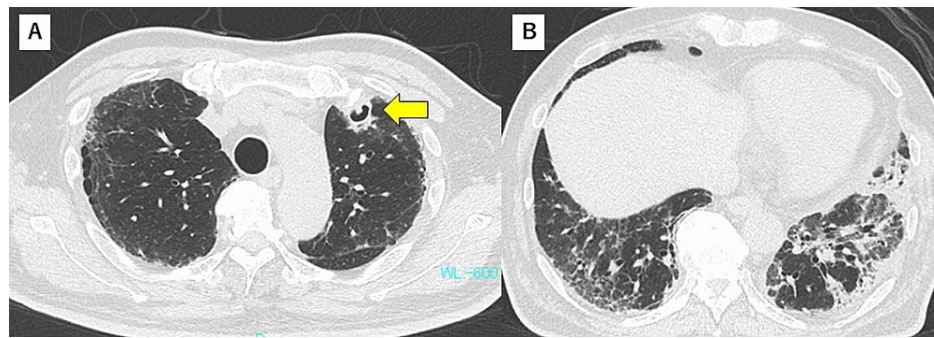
Chest CT findings on day 42
